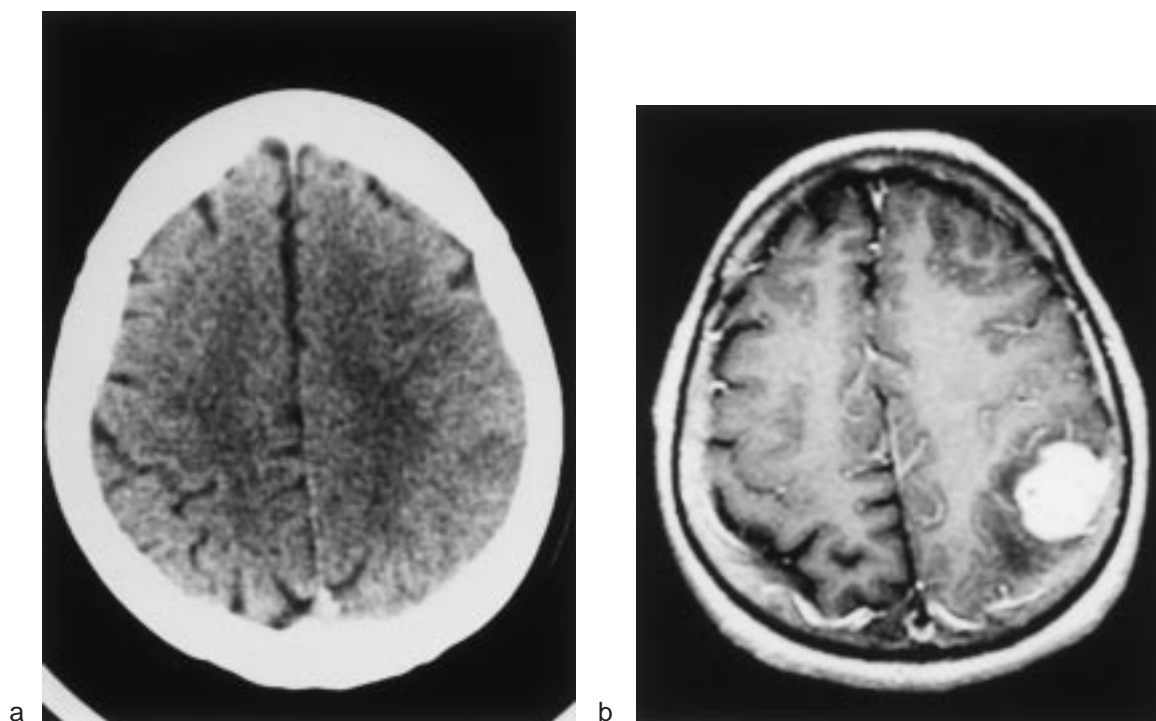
(a) Non-contrast head CT of a 63 year old woman with acute onset of right arm weakness and aphasia. Note subtle left parietal sulcal effacement. (b) Gadolinium enhanced T1 weighted brain MRI scan obtained two weeks later reveals an enhancing left parietal lobe mass lesion.
